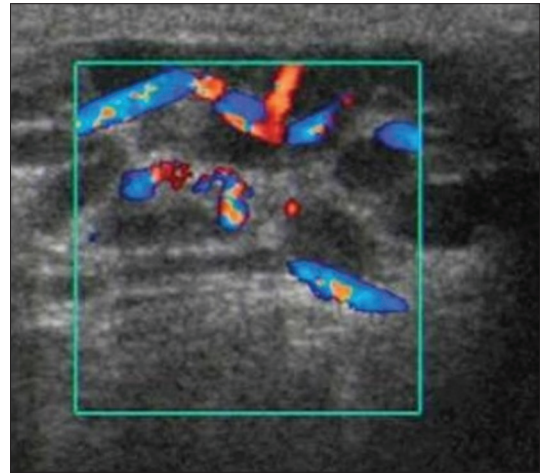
High-resolution color-flow Doppler ultrasound image demonstrating varicocele surrounding the left testis
